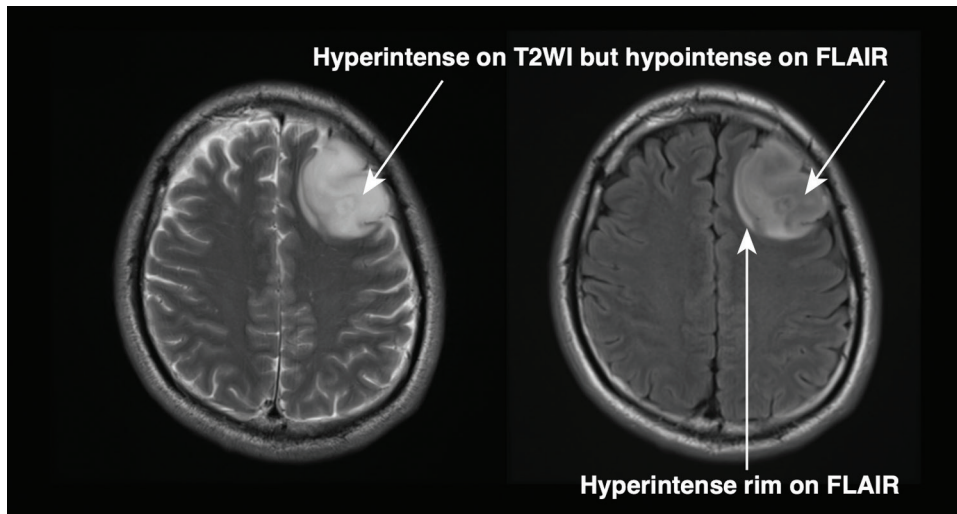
We present a typical example that exhibits the T2-FLAIR mismatch sign. This is a 28-year-old male with an *IDH*-mutated astrocytoma arising at the left middle frontal gyrus. The T2-hyperintense region turns hypointense on FLAIR with a hyperintense rim surrounding the lesion.
